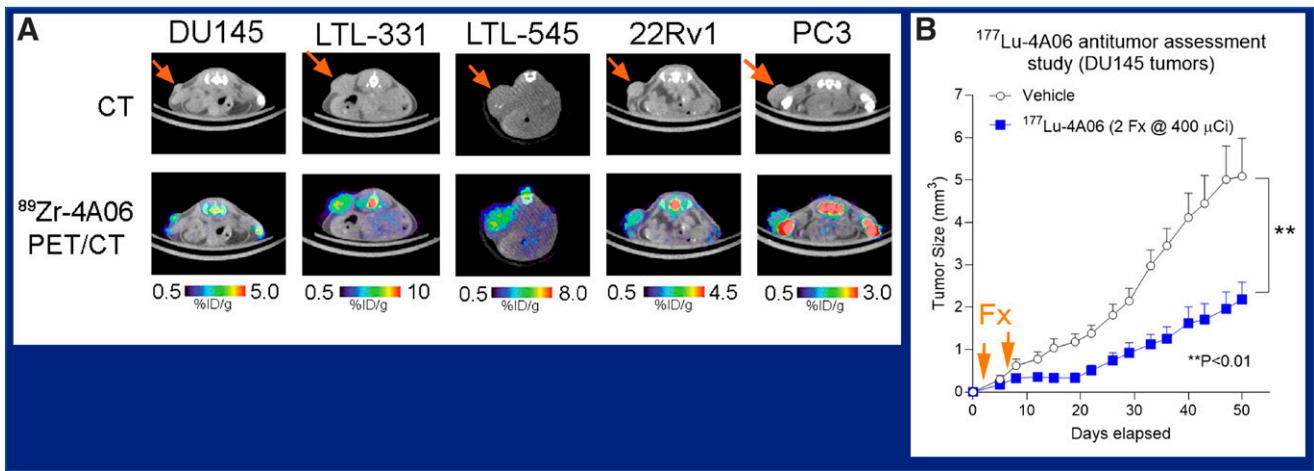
CDPC1 as a novel target for radioligand therapy in metastatic castration-resistant prostate cancer refractory to treatment with PSMA-directed radioligands. (A) CT (top row) and ⁸⁹Zr-4A06 PET/CT (bottom row) images in tumor cell lines (left to right): DU145, LTL-331, LTL-545, 22Rv1, and PC3. (B) Labeling the 4A06 agent with ¹⁷⁷Lu led to growth inhibition, showing promise for CFPC1-directed therapy.
